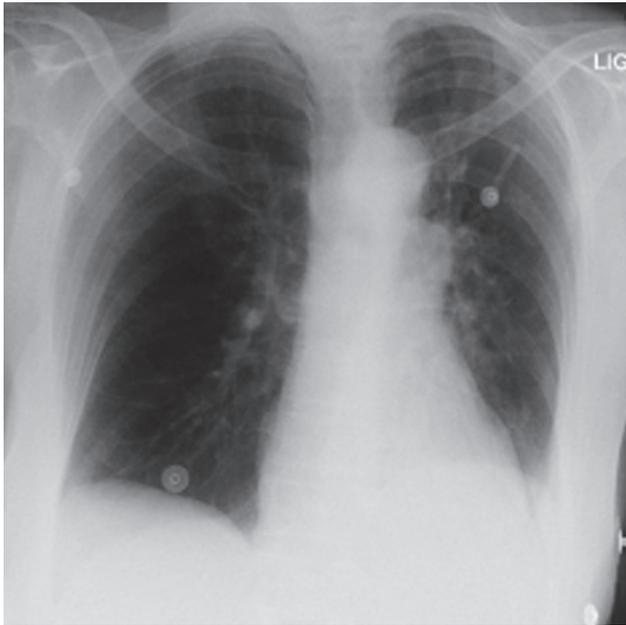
chest radiograph on admission showing left lower lobe atelectasis
